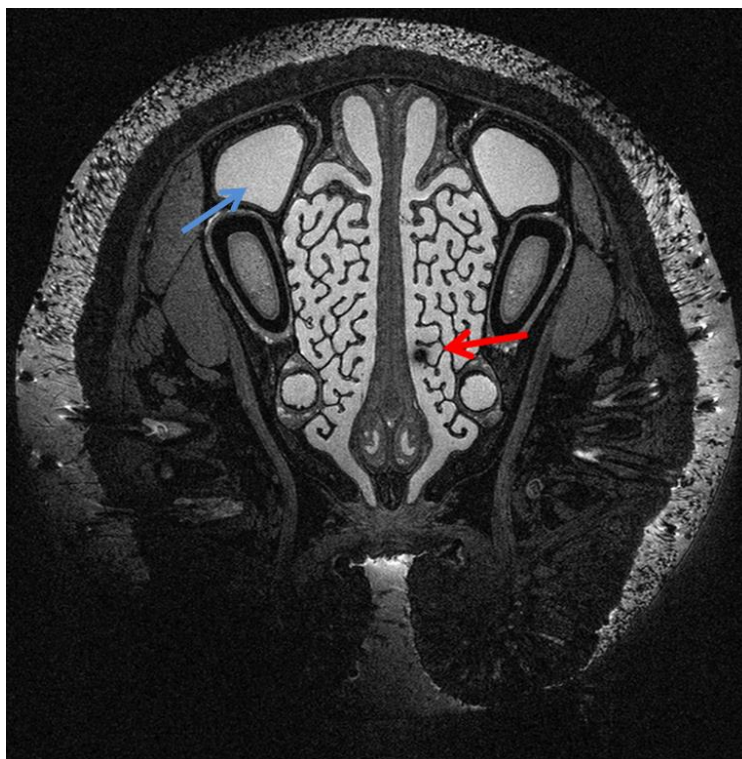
Transverse MRI slice in the eastern grey squirrel nasal airway. Blue arrow indicates liquid-filled airways; red arrow points to an air pocket.
